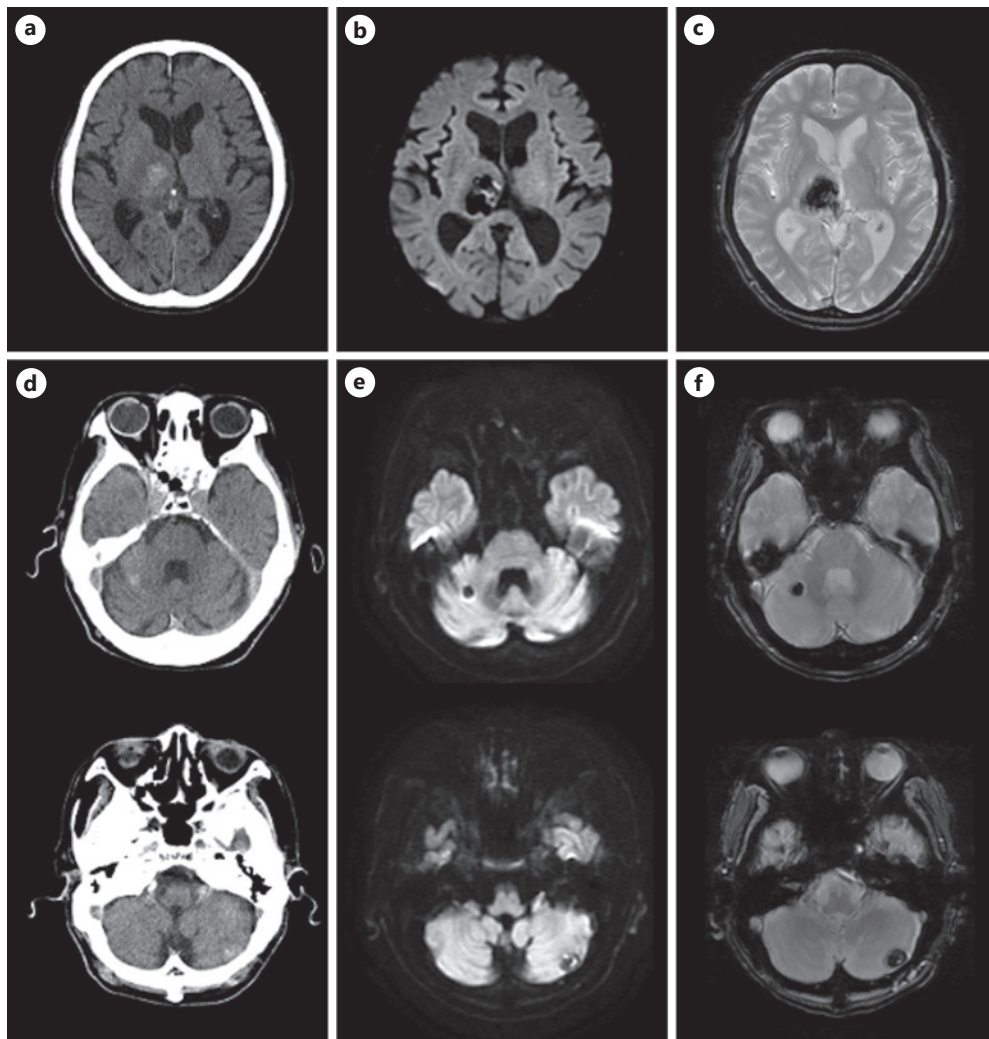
Radiological imaging of current case. a–c Right thalamic hemorrhage as a patchy hyperdense lesion on unenhanced CT (a) and a hypodense lesion on DWI (b) and T2*-weighted conventional GRE imaging (c). d–f Hemorrhages in the bilateral hemispheres are seen as spotty lesions on unenhanced CT (d) and hypodense lesions on DWI (e) and T2*-weighted GRE images (f). GRE, gradient-echo; CT, computed tomography; DWI, diffusion-weighted imaging.
